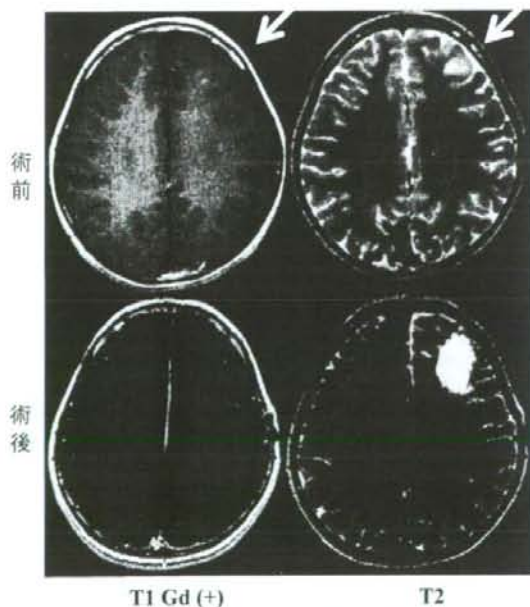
症例の術前・術後 MRI 病変を含む脳回(矢印)を摘出している。
